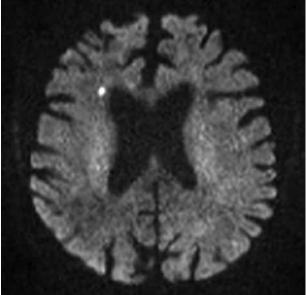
Diffusion-weighted magnetic resonance imaging with small subcortical ischaemic lesion in right frontal lobe
